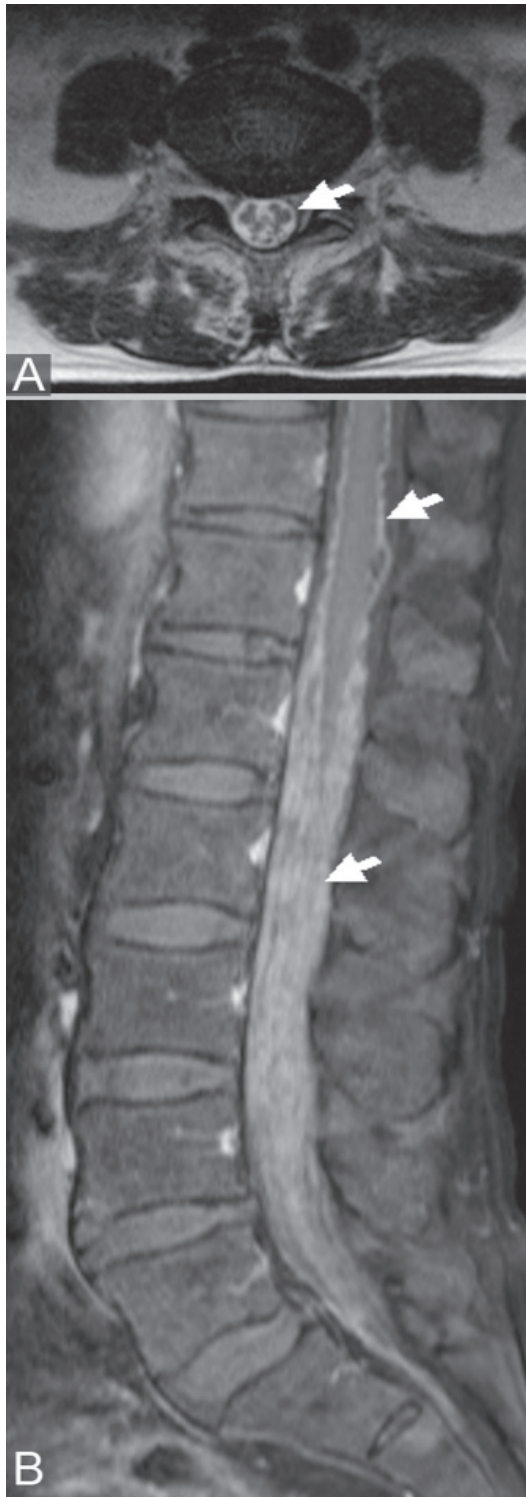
Axial (A) T2W and post contrast sagittal T1W MR imaging of spine of a 75 years old man with cytology positive neoplastic meningitis secondary to non Hodgkin's lymphoma, shows clumping of lumbo-sacral roots and diffuse meningeal enhancement (arrow).
